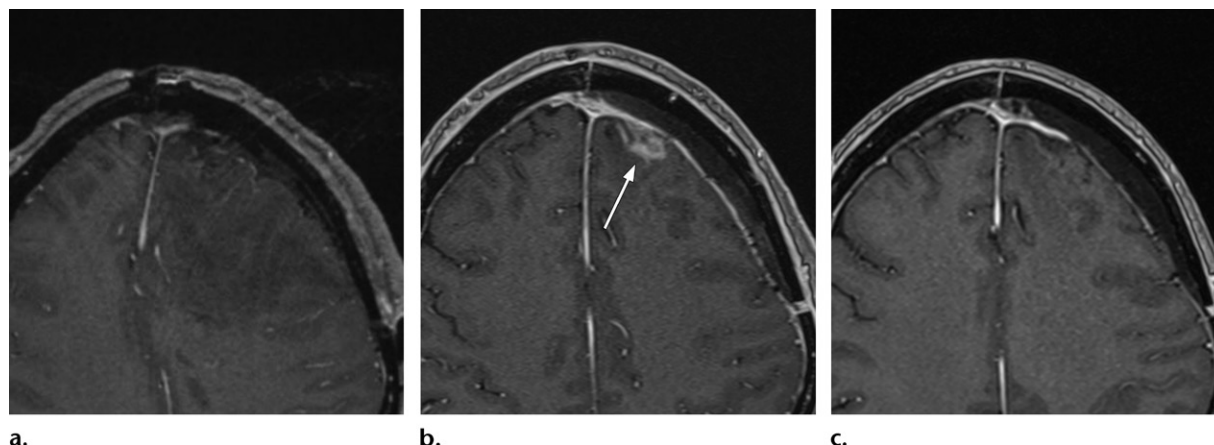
Pseudoprogression in a 52-year-old woman who received chemoradiation therapy (CRT) (standard-fractionation type) with temozolomide after gross total resection of the enhancing component of a glioblastoma in the left frontal lobe. (a) Axial contrast-enhanced T1-weighted image immediately after gross total resection of the tumor. (b) Axial contrast-enhanced T1-weighted image 1 month after CRT shows increased enhancement (arrow) around the resection cavity. (c) Follow-up image 4 months after CRT shows spontaneous resolution of the lesion.
